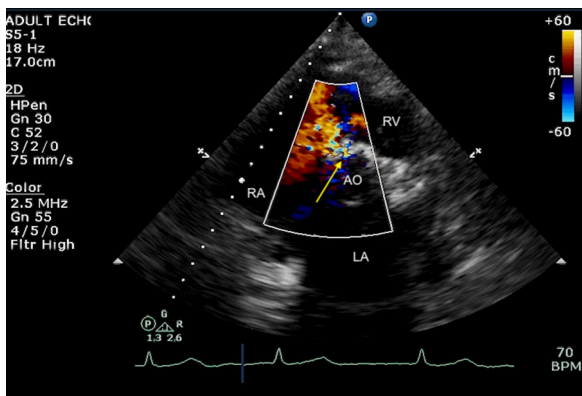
Two-dimensional TTE parasternal short-axis view with color flow Doppler demonstrates the ARV fistula (arrow) with flow from the AO to the RV. AO, Aorta; LA, left atrium.
